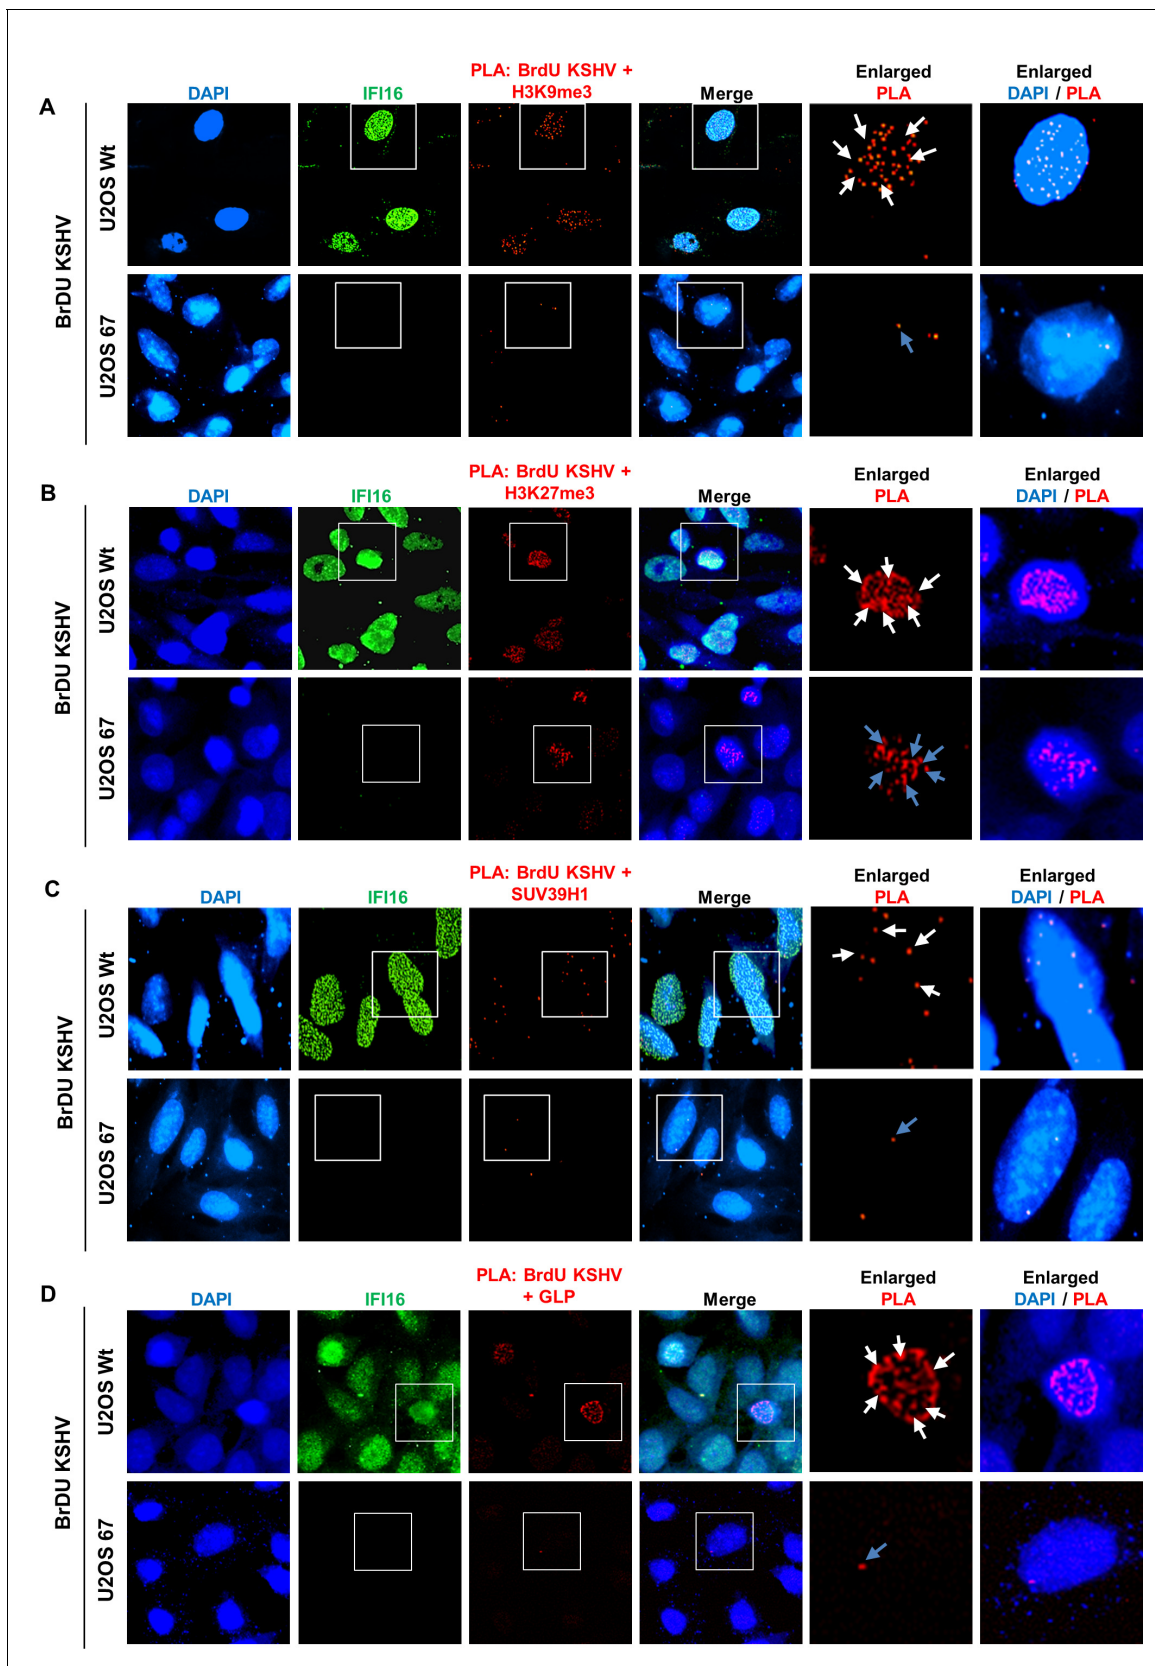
Proximity Ligation Assay (PLA) demonstrating the reduced recruitment of H3K9me3, GLP and SUV39H1 but not H3K27me3 onto the KSHV genome by IFI16 KD. (A) U2OS wt and U2OS 67 (IFI16 KO) were infected with BrdU genome labeled KSHV for 24 hr and PLA was performed to assess
